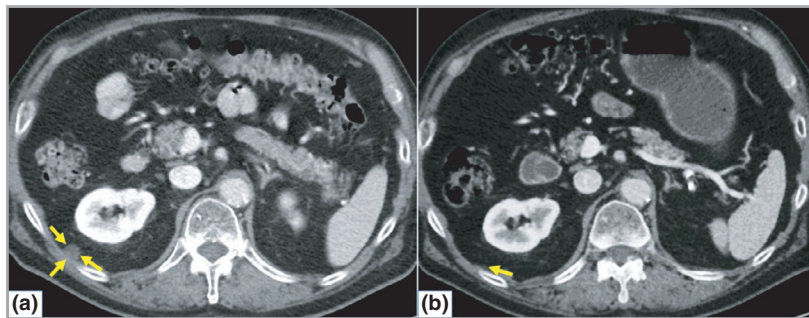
A patient with metastatic Merkel cell carcinoma (MCC) who had an objective response to somatostatin analogue (SSA) therapy. The patient was an 84-year-old man initially diagnosed with a stage IIIA MCC of his right lower extremity, who later developed metastases in the right common iliac lymph node, and a retroperitoneal lesion, shown by the yellow arrows (a). Somatostatin receptor scintigraphy (SRS) demonstrated mild ^{111}In -pentetreotide uptake on his MCC metastases. He received palliative single-fraction radiotherapy to the iliac lymph node and also started an SSA for systemic control. Three months after initiation of SSA, the nonradiated retroperitoneal nodule resolved (b), suggesting response to SSA. The response was ongoing when he died from MCC-unrelated causes of gastrointestinal bleeding from diverticulosis around 8 months later.
